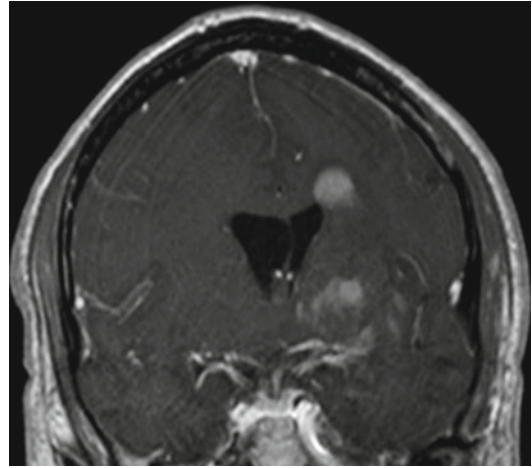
Magnetic resonance imaging (MRI) of the brain showed multiple periventricular lesions consistent with primary central nervous system lymphoma with vitreoretinal involvement
